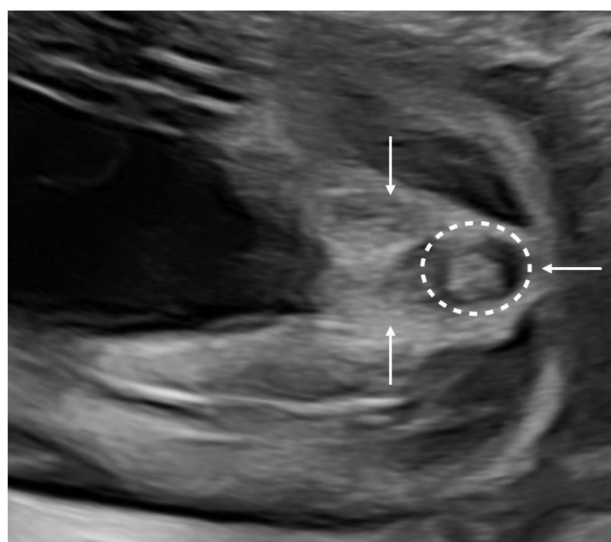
2D grayscale ultrasound image of “target sign” in the tangential view of fetal perineum.
